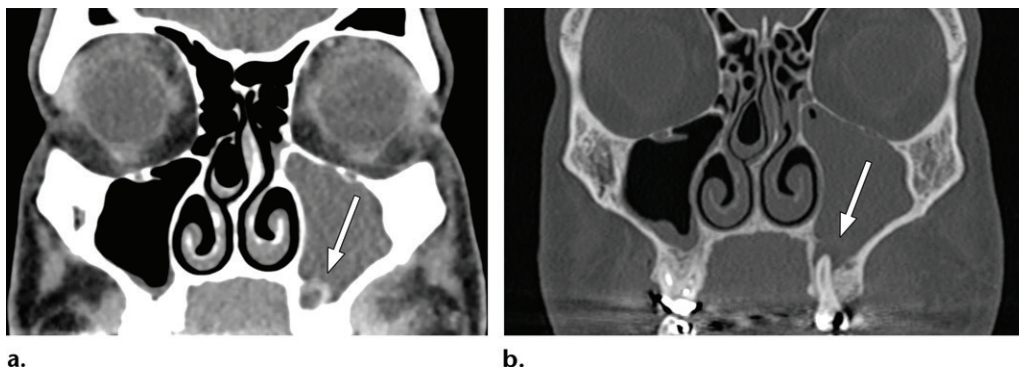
Periapical abscess. (a) Coronal contrast-enhanced CT image (soft-tissue window) demonstrates a hypoattenuating fluid collection with peripheral enhancement (arrow). (b) Coronal CT image (bone window) shows bone loss around the root apex with discontinuity of the maxillary sinus floor (arrow). Both images show complete opacification of the left maxillary sinus, consistent with odontogenic sinusitis.
